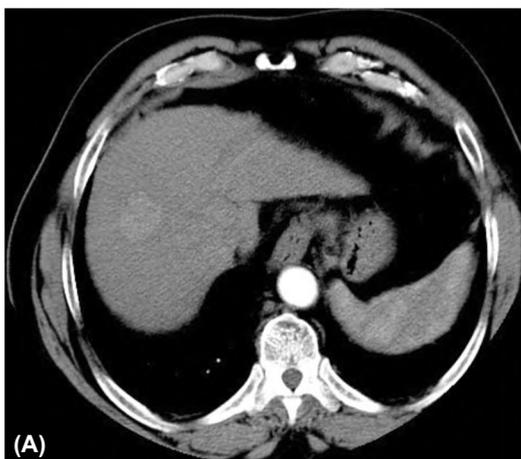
(A, B): A 66-year-old male patient with hepatitis C diagnosed as HCC involving right hepatic lobe segment VIII shown in pre-treatment triphasic CT-scan. (A) Arterial phase image showed right hepatic lobe segment VIII enhancing focal lesion, measuring about 2.8cm in maximum diameter. (B) Delayed phase image showed corresponding washout, suggestive of HCC.
